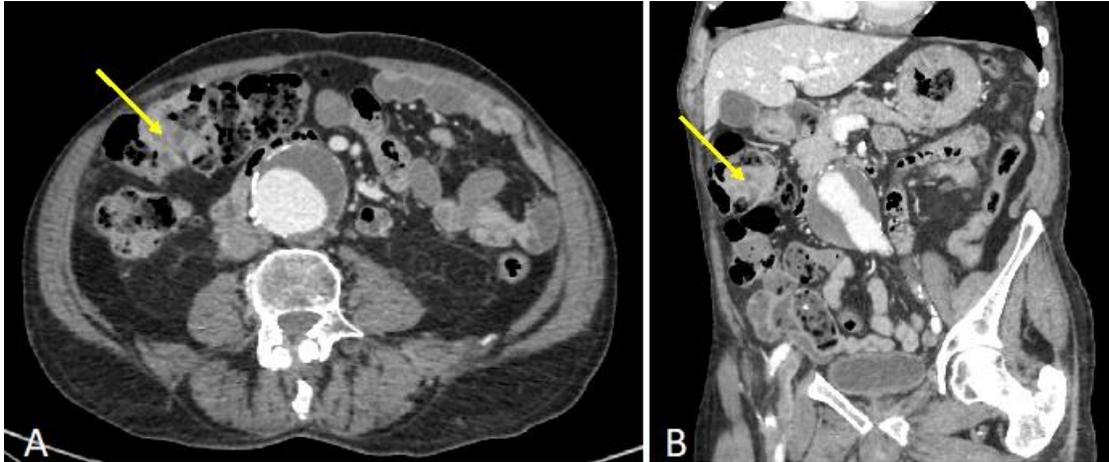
Preoperative CT scan: A) transverse and B) coronal view showed a 5.8×5.4 cm infrarenal aortic aneurysm and thickening of the colon wall at the hepatic flexure (arrow).
